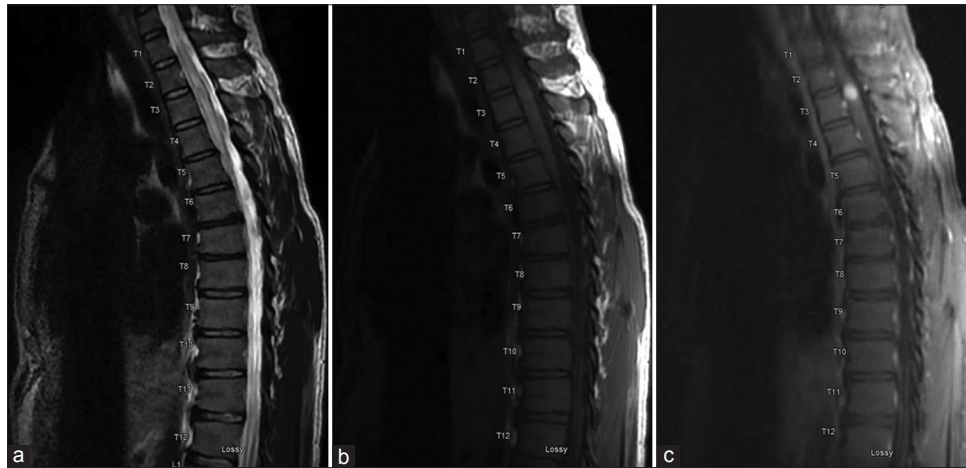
Initial magnetic resonance imaging of the thoracic spine demonstrates a 9-mm homogeneously-enhancing intramedullary spinal cord lesion with significant edema within the spinal cord above and below the lesion. Sagittal T2-weighted image (a), sagittal T1-weighted image without contrast (b), and sagittal T1-weighted image without contrast (c) are shown.
